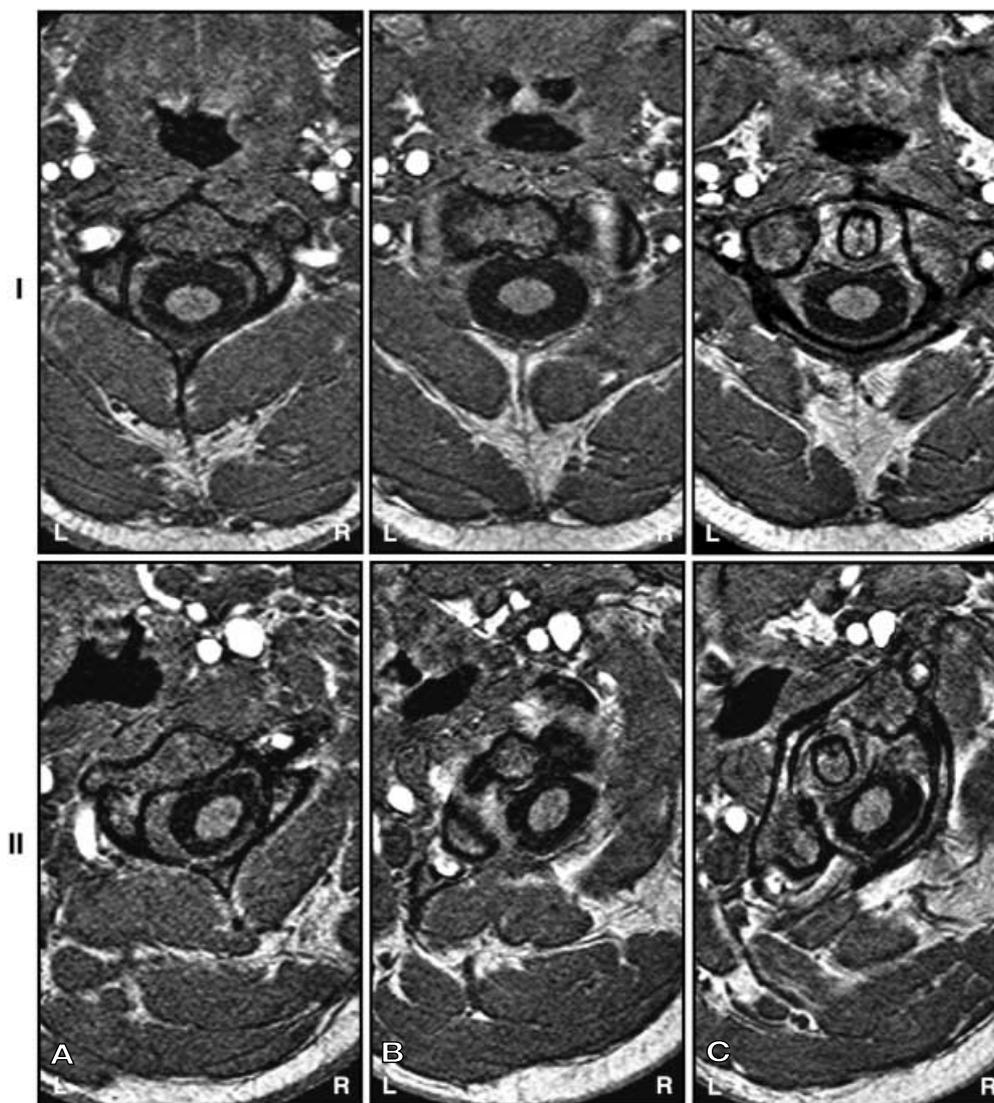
Axial T1-weighted MR images (volunteer no. 3) at the level of A the body of the axis, B the lateral atlanto-axial joints and C the central part of the lateral mass of the atlas with the head in mid-position (*I*) and at maximum left rotation (*II*). In rotation the extradural space cross-sectional area differs per level compared with the mid-position; at the level seen in A there is an increase at the left (ipsilateral) side and a decrease contralaterally, the reverse occurs at the level seen in C, and at the level in B both sides are decreased
